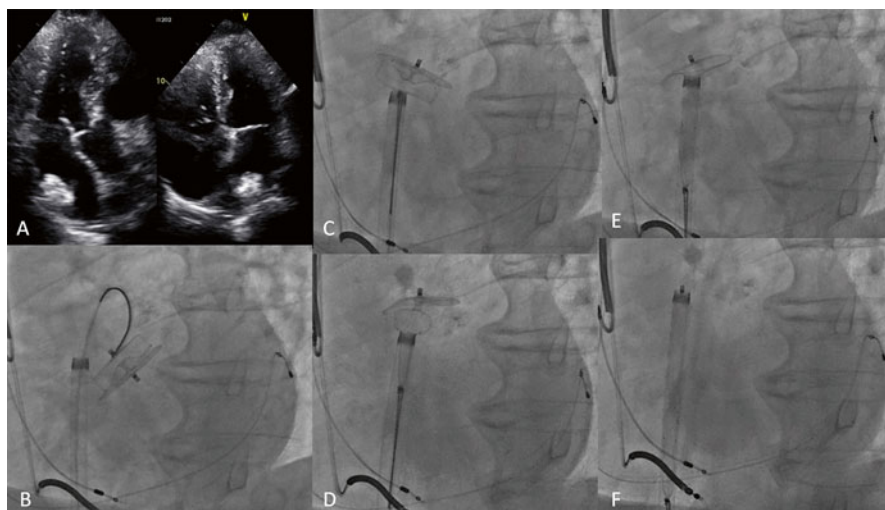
Percutaneous retrieval of embolized 24 mm ACP device lodged in the left atrium. (a) Transthoracic echocardiogram images showing the embolized device (*arrows*). (b) Fluoroscopic image showing a 25 mm gooseneck snare, which had been delivered through a 5F EBU guide within a 16F 80 cm Checkflo sheath, grabbing the distal endscrew of the ACP device. (c) The device was pulled in against the 16F sheath in a coaxial manner. (d) The device was then pulled in firmly, with the lobe partially retrieved. (e) The lobe was entirely retrieved. (f) The disk was entirely retrieved
